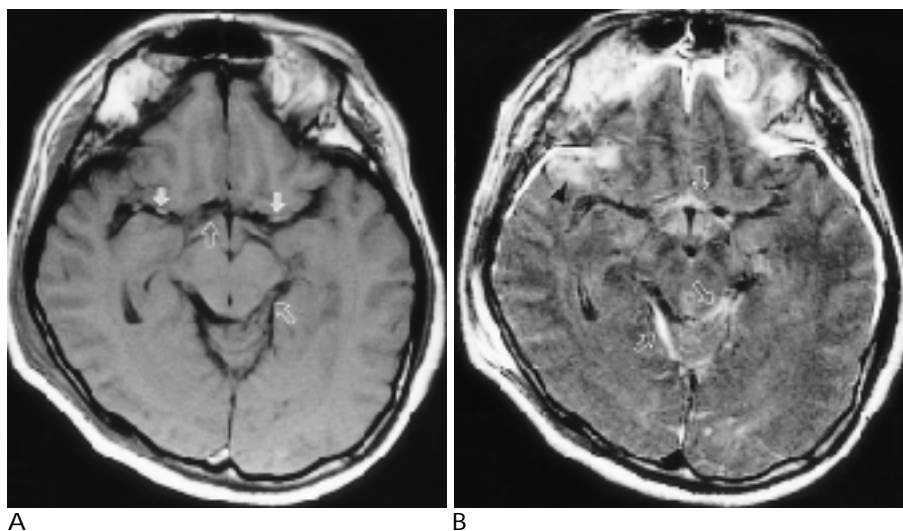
Acute subarachnoid hemorrhage in 39-year-old man by trauma. T1-weighted and FLAIR MR images were obtained 3 days after trauma.
